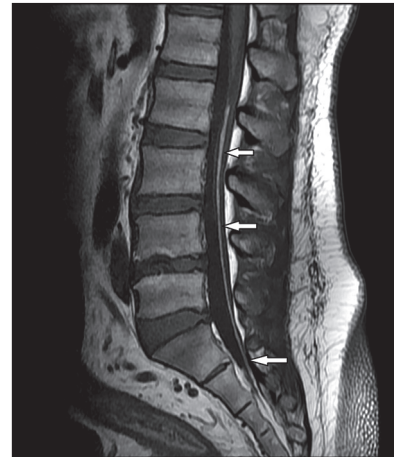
Sagittal T1 weighted MRI image demonstrating FFT as a long cord like hyperintense intrathecal structure isointense to the subcutaneous fat in patient 2. No significant slackness of the FFT is noted despite reduced disk height
